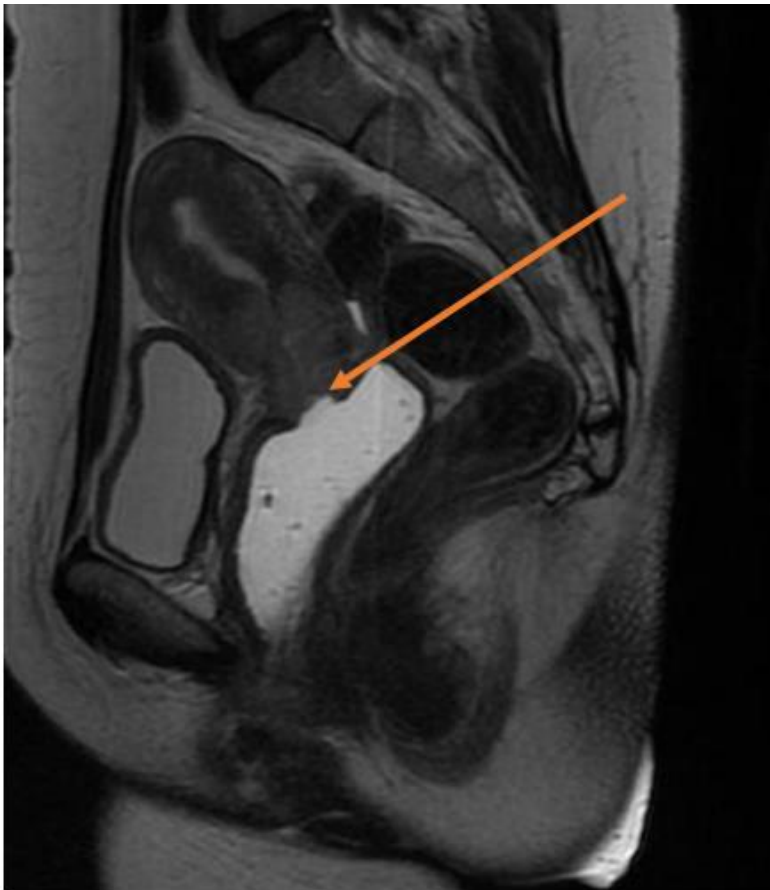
Cervical carcinoma extending into the upper anterior vagina. Sagittal pelvis MRI T2W
